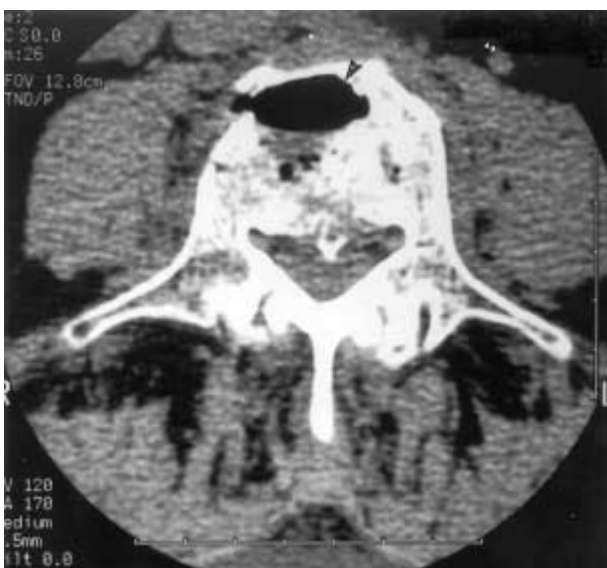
Axial CT scan of L4 vertebral body showing intraosseous air (see arrow).
